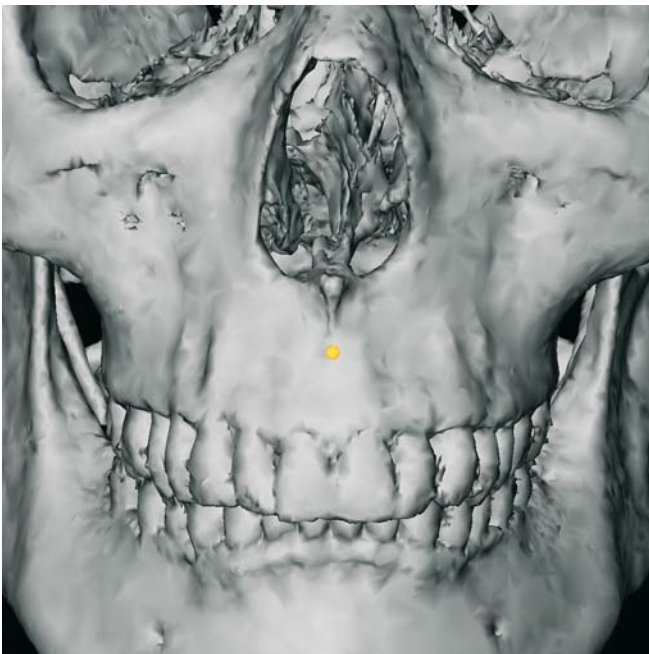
A-Point. Frontal view (3-D CT, patient K.C.)
